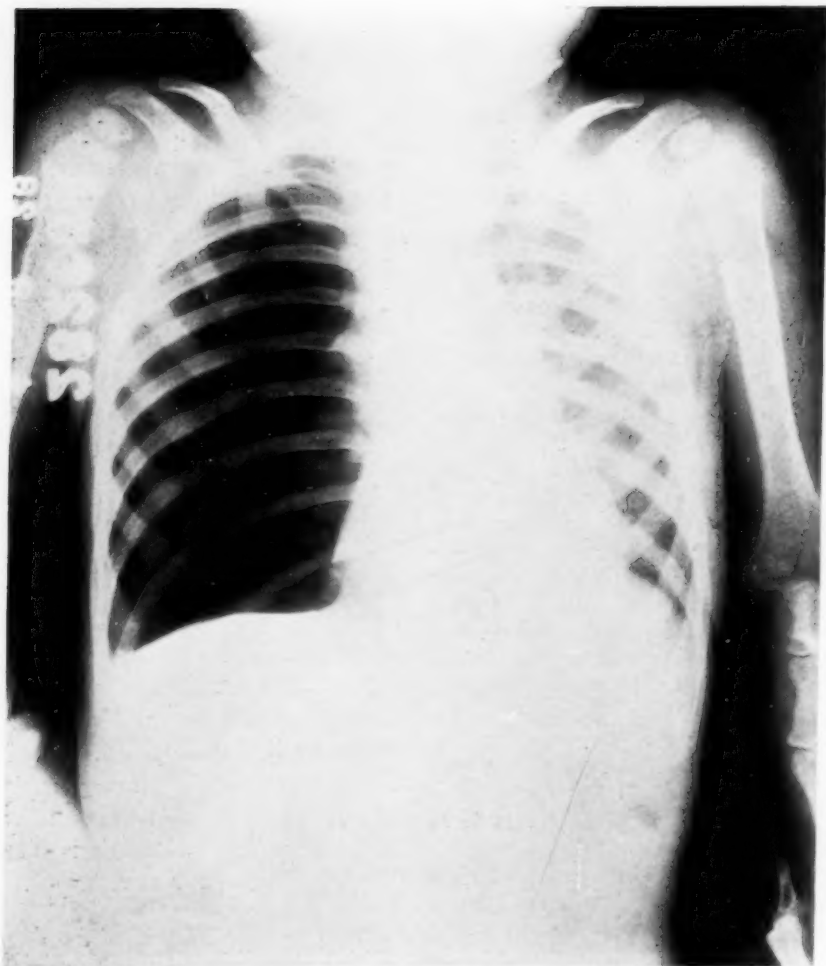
Case 8: An infant whose roentgenogram shows what appears to be a spontaneous pneumothorax, congenital or acquired—probably a huge bulla. See Fig. 10.
